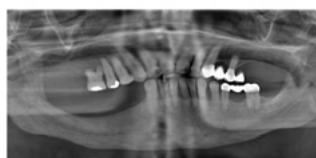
panoramic x-ray from 11/2011 with general bone condensation and homogenization as well as reduction of the osteolysis.
